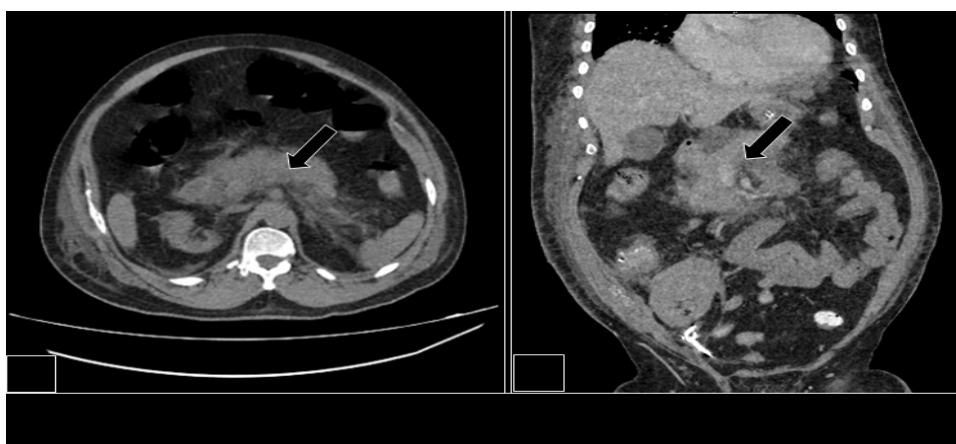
Non contrast CT demonstrating peripancreatic inflammation
